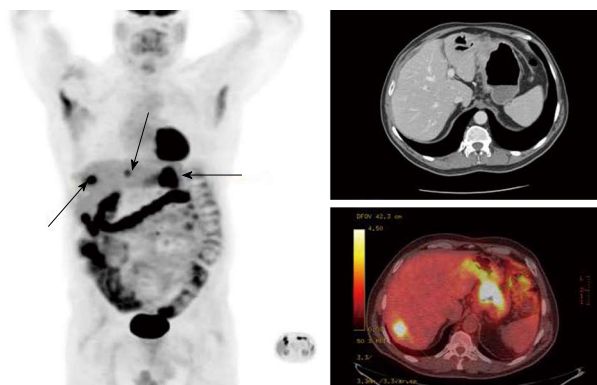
(¹⁸F) 2-fluoro-2-deoxyglucose-positron emission tomography/computed tomography image of a patient with a proximal gastric cancer and occult liver metastasis. The liver lesion was not identified on the corresponding staging computed tomography.
